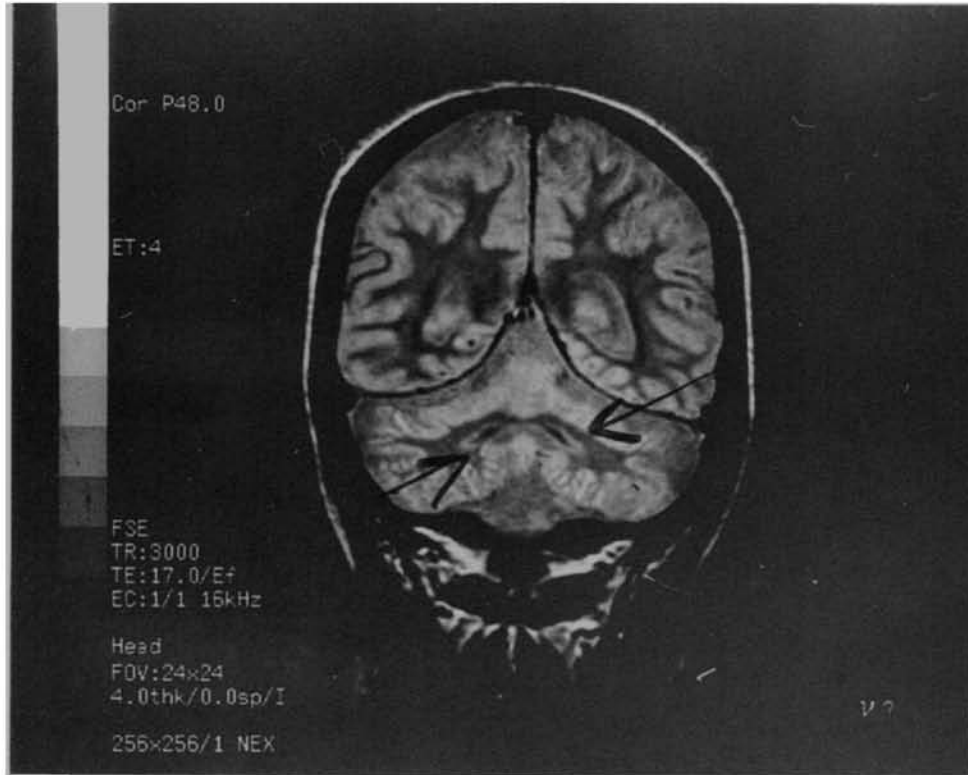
Coronal (top) and sagittal (bottom) slices of B.R.'s magnetic resonance imaging scan showing extensive cerebellar cortical atrophy and intact deep cerebellar nuclei.
